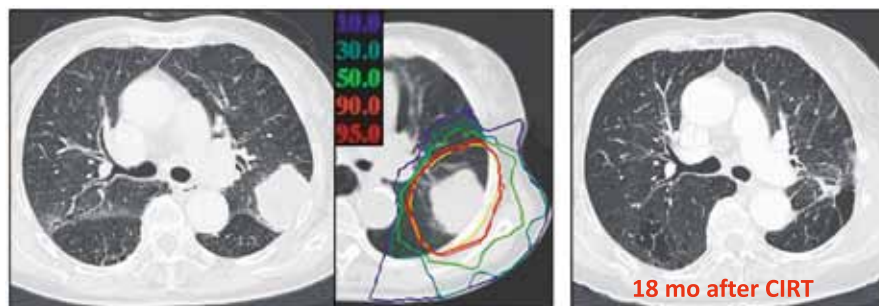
Stage IB, squamous cell carcinoma. Single fractionation carbon ion radiotherapy was performed with 40GyE. Prior CT (A), dose distribution map (B), and CT at 18 months after carbon ion radiotherapy (C). CT scan at 18 months shows tumor shrinkage and slight lung fibrosis.
